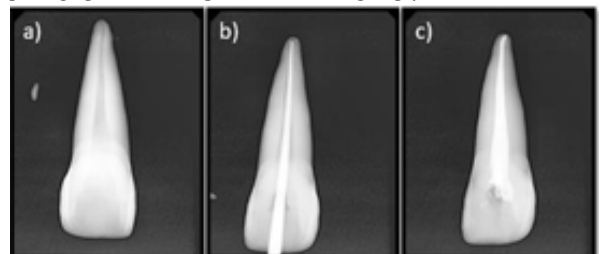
Extra-oral Root Canal Treatment with #11: Pre-operative X-ray(a), Master cone selection(b), Obturation(c)
